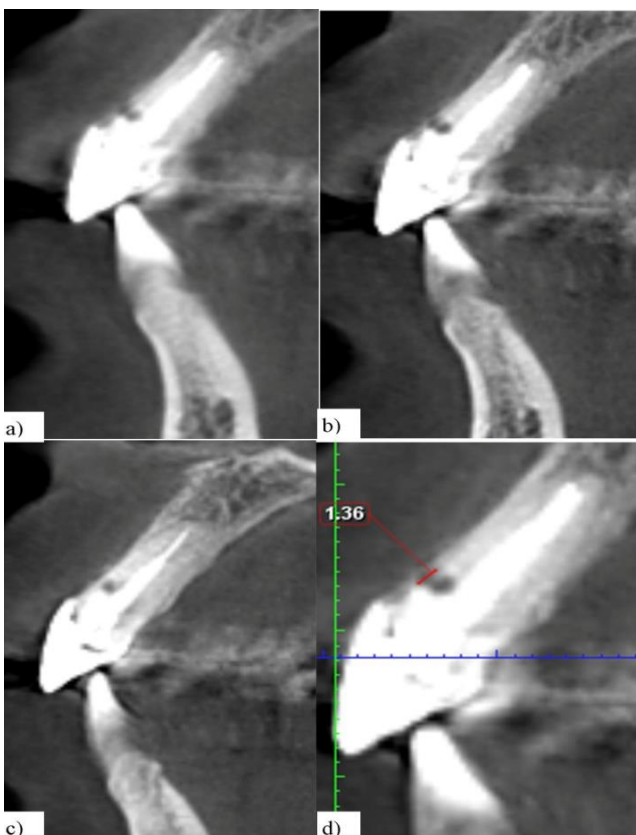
Sagittal sectional images of a CBCT scan through tooth UR1 from mesial to distal. (a) and (b) showing a
